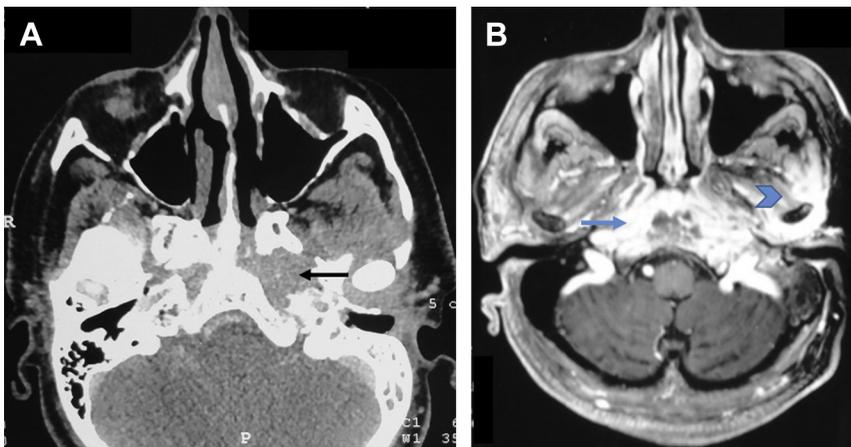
A 52-year-old uncontrolled diabetic with *Aspergillus fumigatus* infection involving the skull base. Axial contrast-enhanced CT scan (A) shows infiltrative soft tissue (arrow) destroying the left petrous apex. Axial post-contrast T1 fat-suppressed magnetic resonance (MR) image (B) shows extensive infiltrative enhancing soft tissue in the skull base involving clivus (arrow in B) and bilateral petrous apex and extending into left masticator space and left temporomandibular joint (arrowhead in B).
